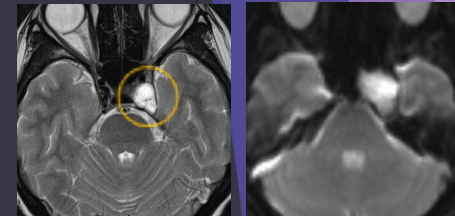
MRI T2 (Left), MRI DWI (Right)
